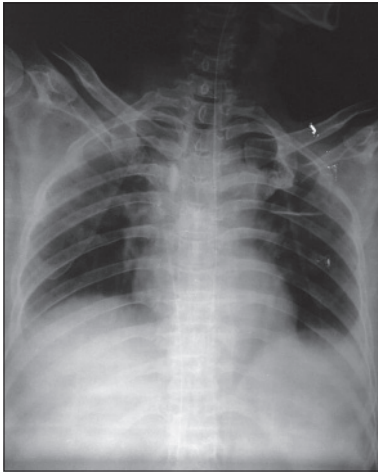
Chest X-ray showing guide wire of catheter had entered in the inferior vena cava (IVC) via the right internal jugular vein
